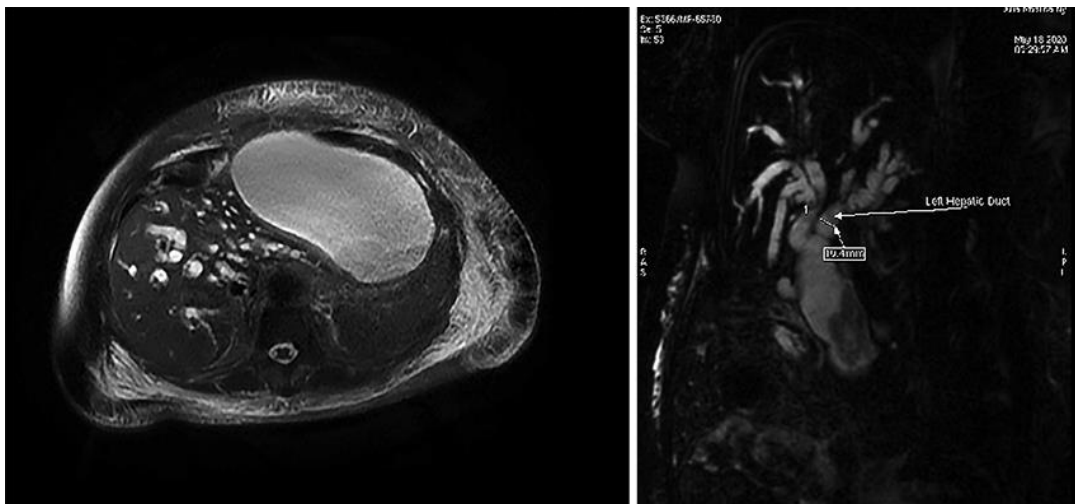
MRI-magnetic resonance cholangiopancreatography showing a pancreatic pseudocyst and a dilated common bile duct with a large stone.
